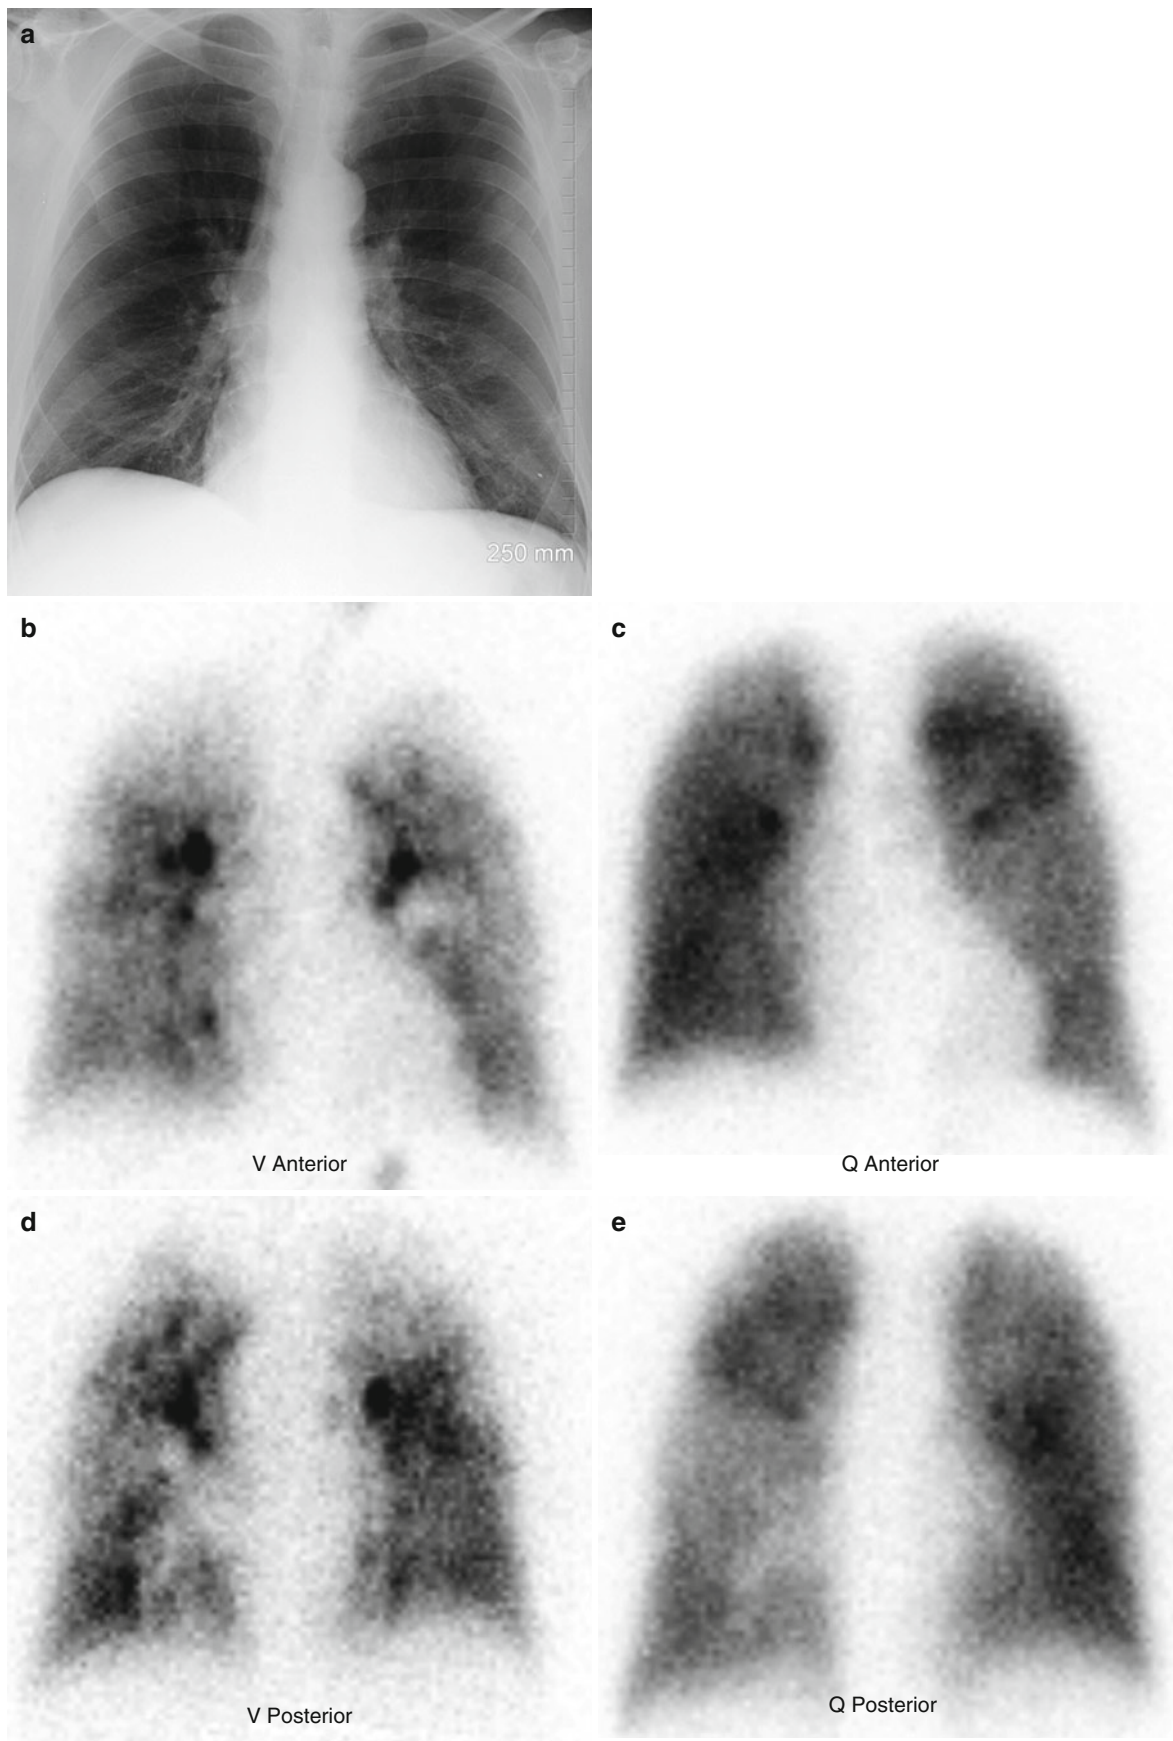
Multiple matched V/Q abnormalities related to underlying airways disease. Normal chest radiograph (a). Heterogeneous ^{99m}Tc DTPA ventilation (*left panel: b, d, f, h*) and heterogeneous ^{99m}Tc MAA perfusion (*right panel: c, e, g, i*)
